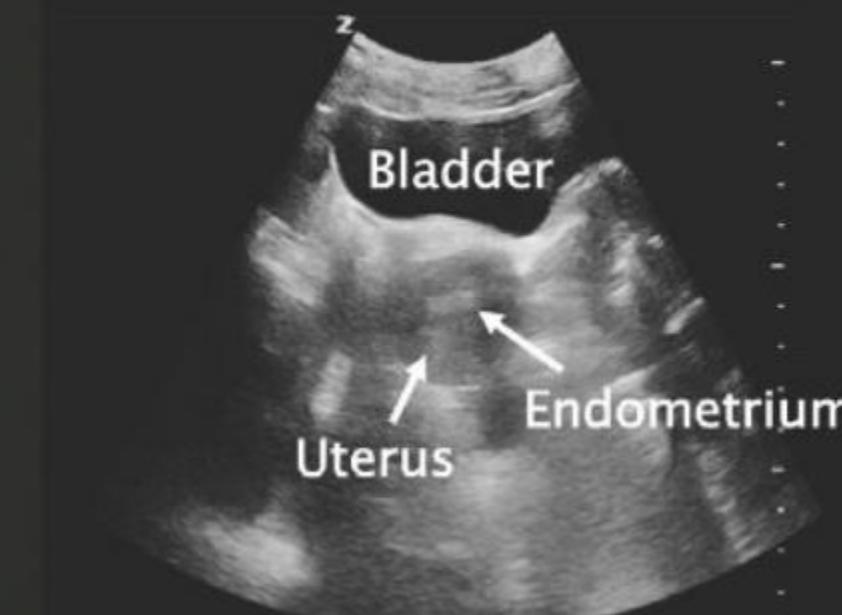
Simultaneous hysteroscopic and transabdominal ultrasound imaging.
